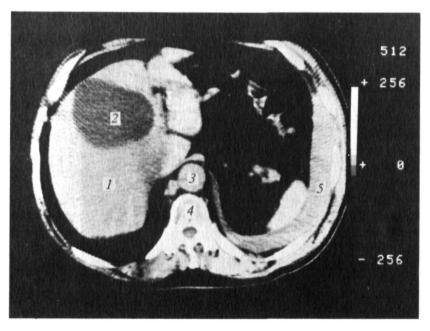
CT scan of hepatic tumour.
